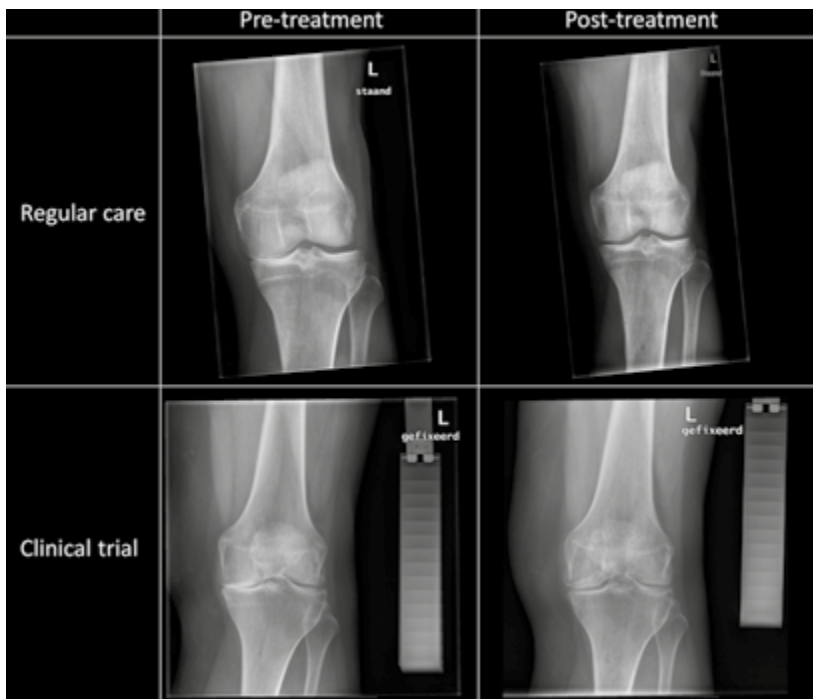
Representative standing AP radiographs of patients treated with knee joint distraction pre-treatment and one year post-treatment. The aluminium step wedge is used to quantify joint space width. [Reprinted by permission of the authors: Jansen et al., *PLoS ONE*, 2020⁴²]
